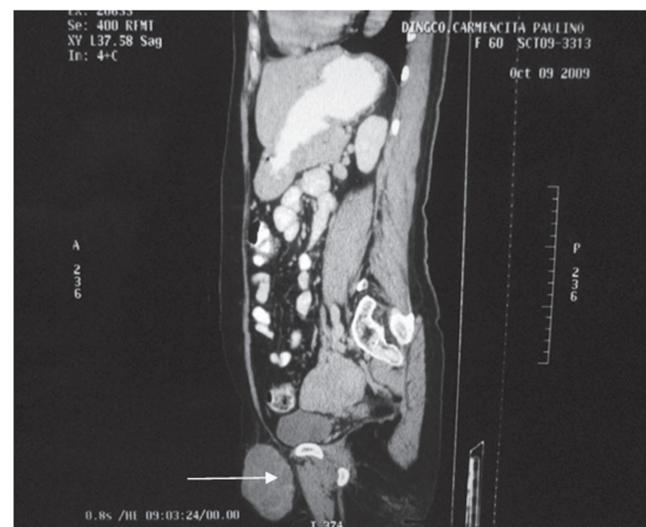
Lateral view of the abdominopelvic CT scan.
